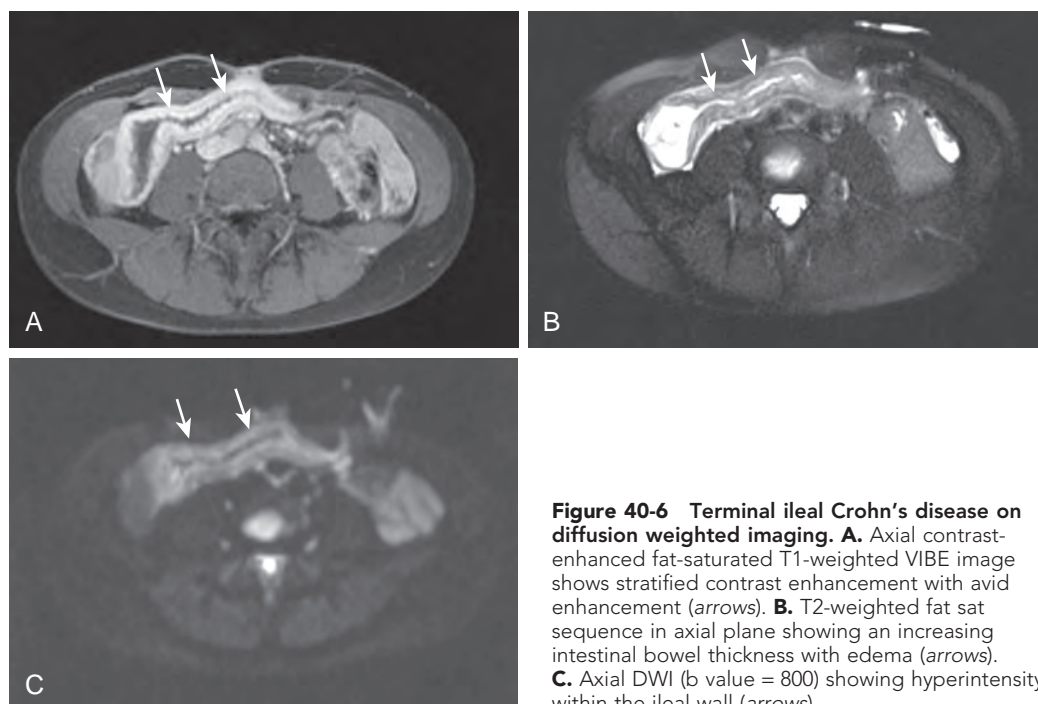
Terminal ileal Crohn's disease on diffusion weighted imaging. A. Axial contrast-enhanced fat-saturated T1-weighted VIBE image shows stratified contrast enhancement with avid enhancement (*arrows*). B. T2-weighted fat sat sequence in axial plane showing an increasing intestinal bowel thickness with edema (*arrows*). C. Axial DWI (*b* value = 800) showing hyperintensity within the ileal wall (*arrows*).
